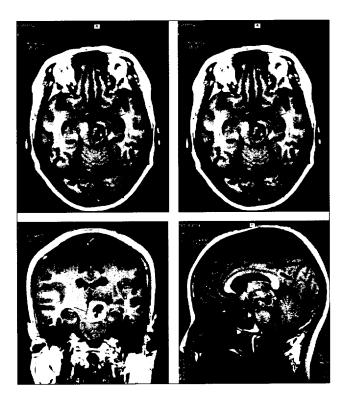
Transverse (T1 and T2), coronal (T2) and sagittal (T2) weighted MRI scan of a patient with a cryptococcal midbrain abscess (arrow)
